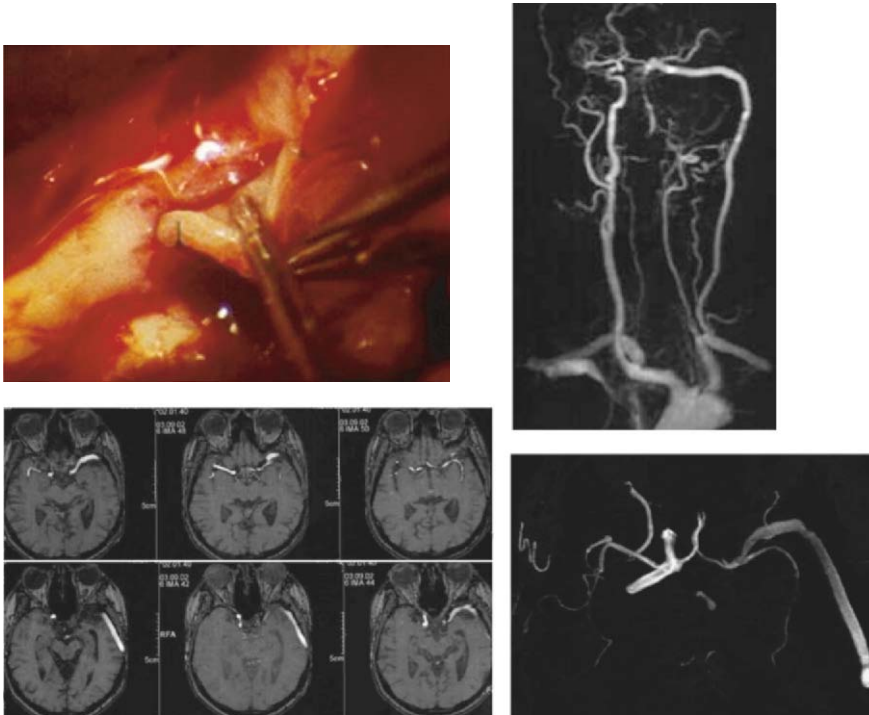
EIAB using extraanatomic vein graft between the left subclavian artery and the left intracranial ICA. Note the first part of the intracranial anastomosis is performed leaving the recipient artery open. MRI followup 7 years later shows patent bypass corresponding to stable clinical situation
